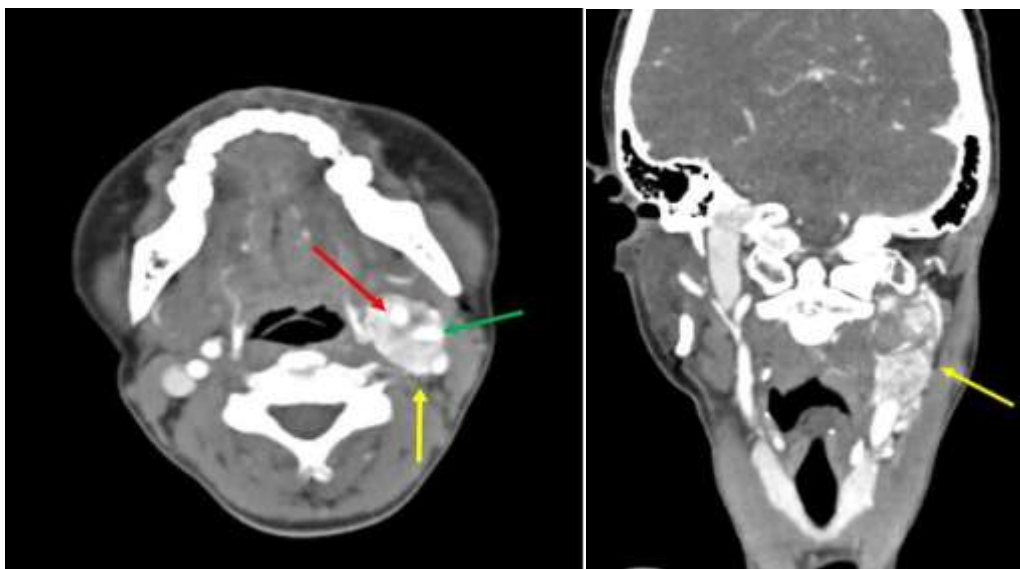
A 37-year old woman, axial (A) and coronal (B) enhanced computed tomography image of the neck demonstrating a carotid body tumor (yellow arrow) with characteristic encasing the internal (green arrow) and external (red arrow) carotid arteries.
